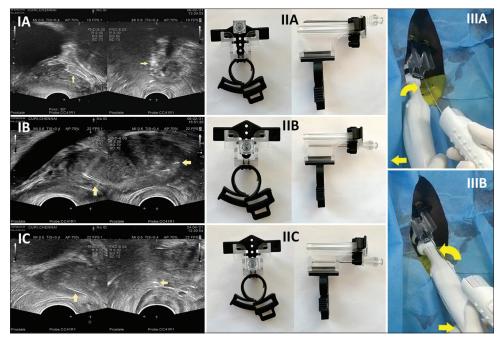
(i) TRUS sagittal and axial images showing systematic biopsy from different sectors of prostate (A) right anterior (B) left middle (C) right posterior (yellow arrows - needle tract). (II) PRECISION POINT Device with coaxial needle at different levels (A-C) anterior, middle and posterior sectors respectively. (III) TRUS probe manipulation for (A) Left lobe - probe rotated clockwise/moved to contralateral side (B) right lobe – probe rotated anticlockwise/moved to contralateral side. TRUS = Transrectal ultrasound
